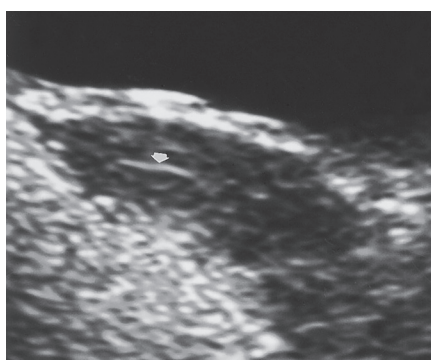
Normal pediatric endometrium. Sagittal Ultrasound image of the uterus in a 2-year-old girl demonstrates a thin endometrium (arrow).
